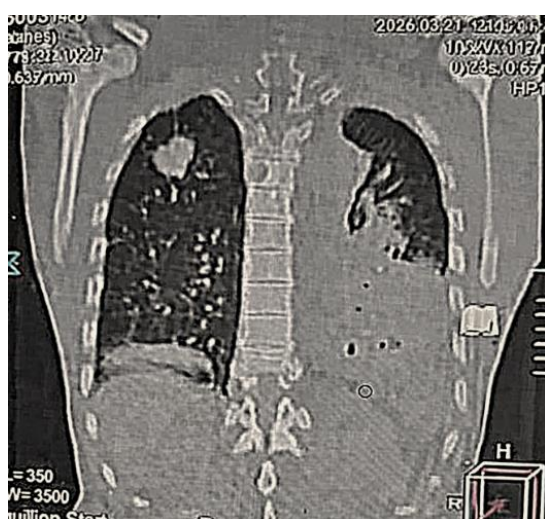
Chest CT scan coronal view.
